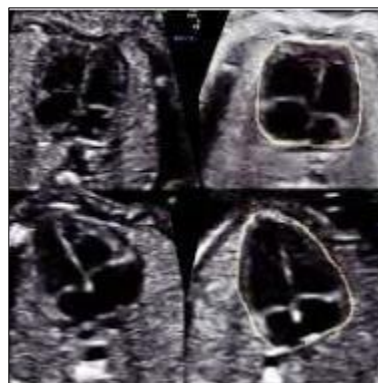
Fetal Echocardiography images of cardiac situs positions. Comparison of heart morphology. Transverse view in 2 fetuses with mesocardia (A and B) and 2 fetuses with levocardia (C and D). In the fetuses with mesocardia (A and B), the heart is positioned at the center of the thorax and the interventricular septum is aligned with the thoracic midline. In both cases, the hearts have a squared-off shape that contrasts with the triangular shape of the hearts in levocardia (C and D)
